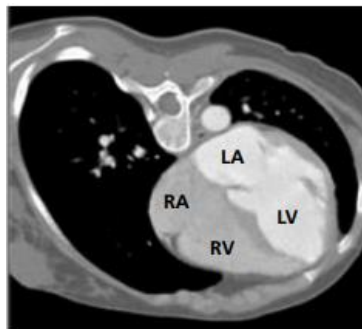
Transaxial CT image showing the left atrium, right atrium, right ventricle and left ventricle [56]
